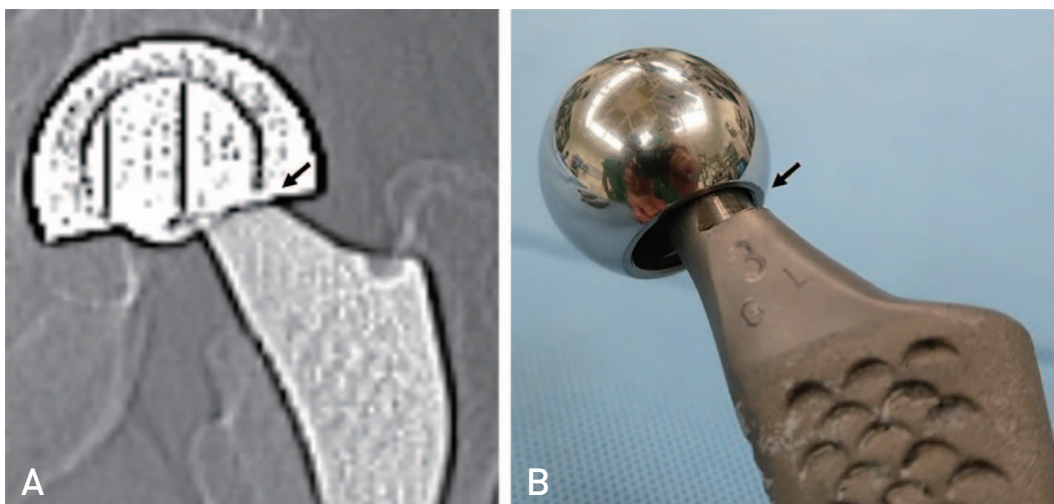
Scout computed tomography image shows a clear outline of the head (A). The lateral margin of the neck is located outside of the edge of the head bore (arrows) (A, B).
